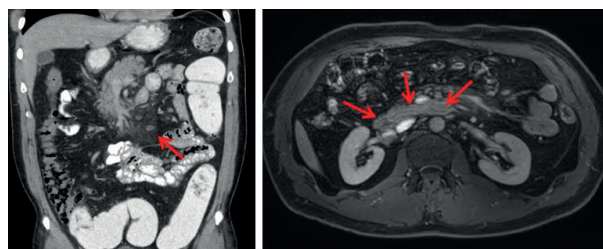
Diffuse mesenteric infiltration around the pancreas and mesenteric lymphadenopathies on CT scan (left) and T1 mDixon in venous phase (right).
